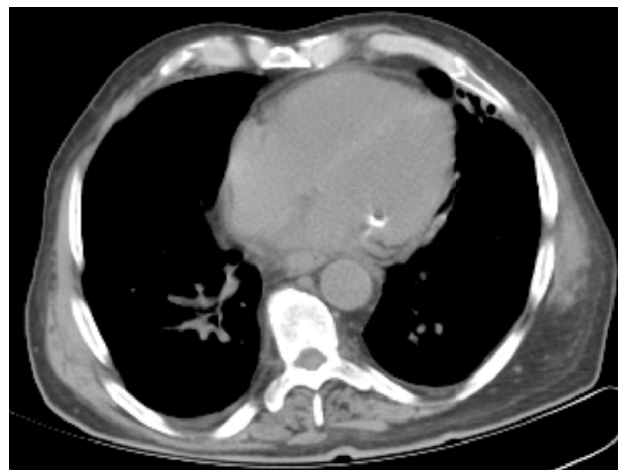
The thoracic contrast-enhanced CT scan of the patient.
